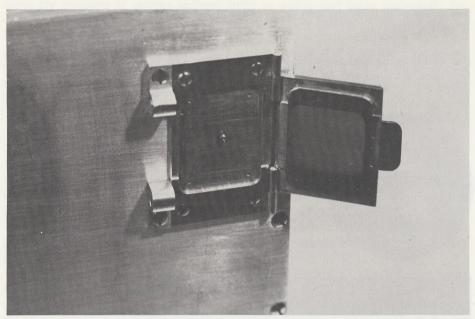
2. At the location of the articulator joints cassettes are attached to the outside of the aluminum plates. Into these filmholders a  $3 \times 4$  cm x-ray film can be inserted.
